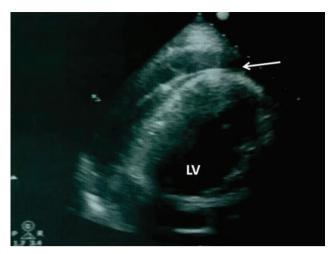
Echocardiographic imaging of pericardial effusion during the procedure.
